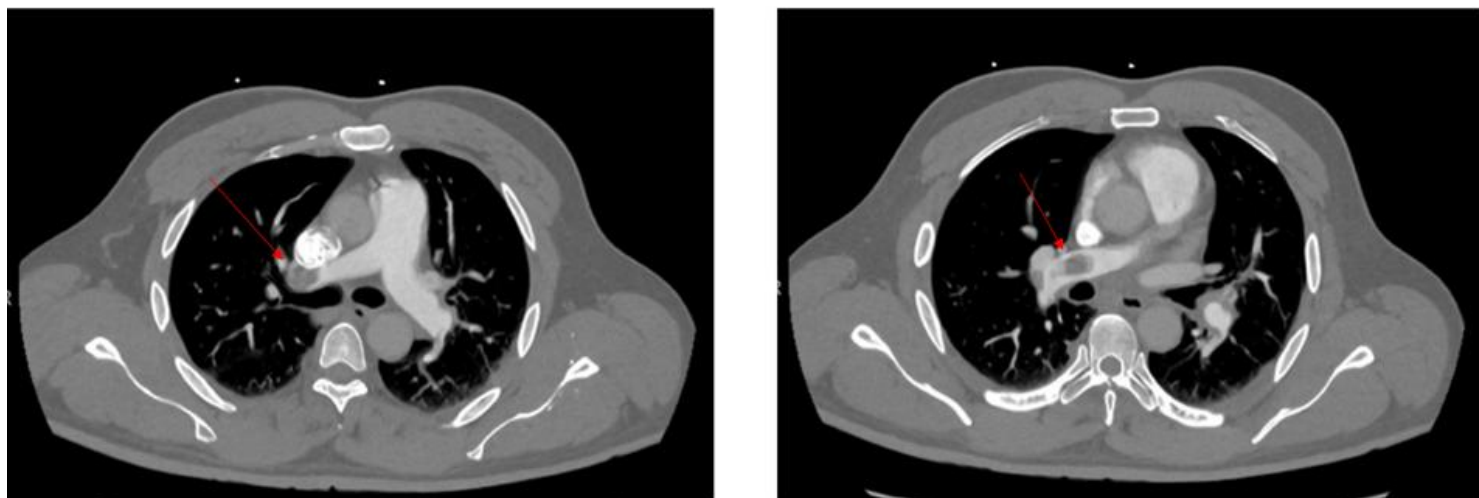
CTA findings of 10+ pulmonary embolisms (two of which are demarcated by red arrows).
